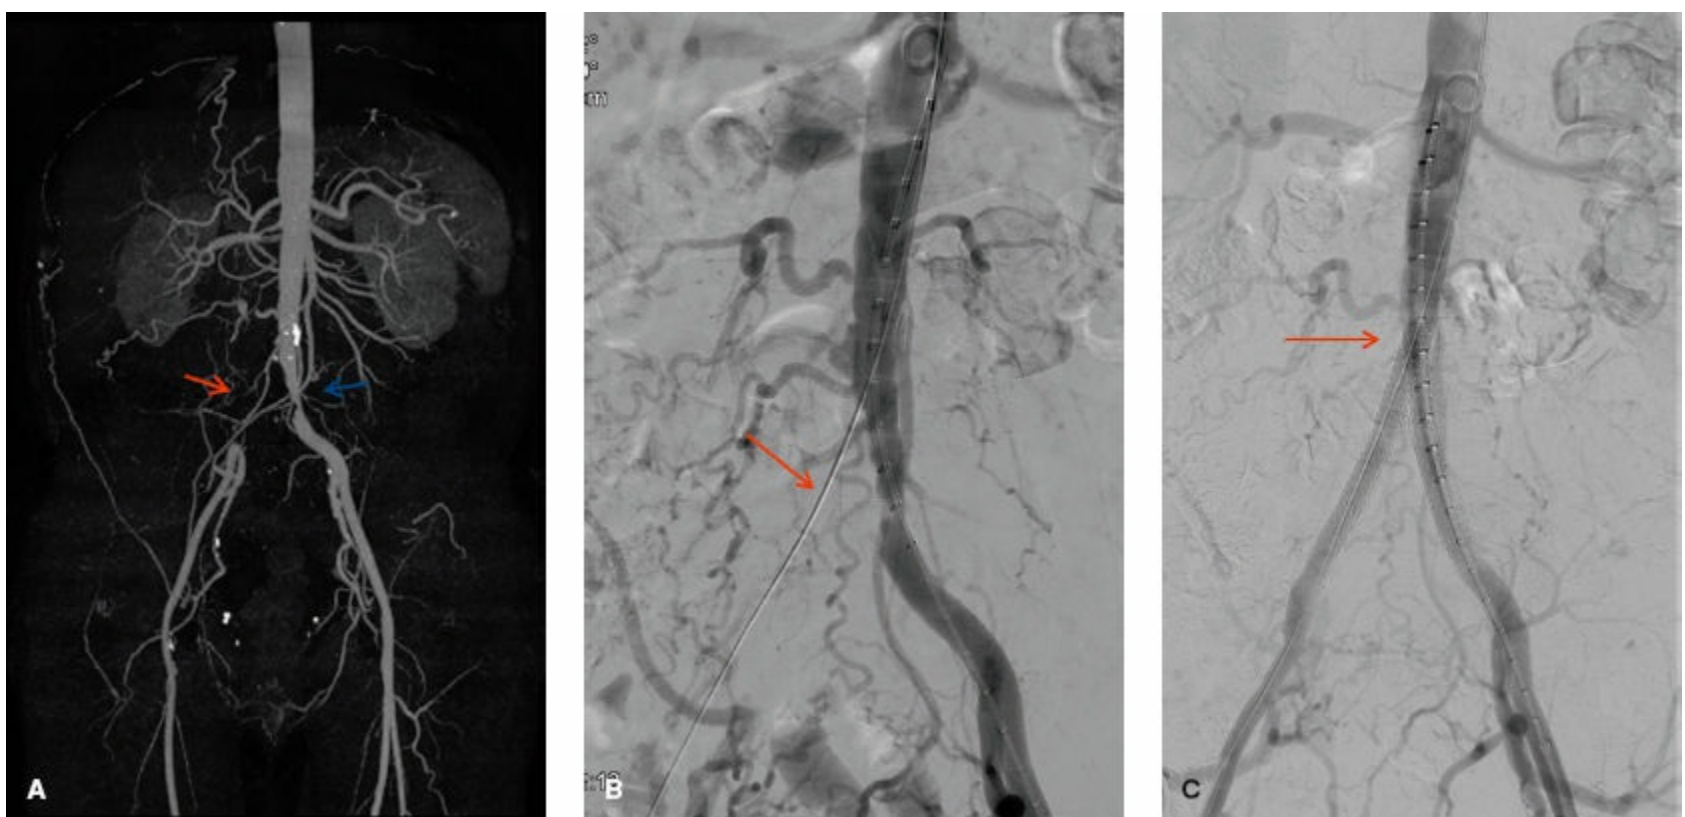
A: CTA 3D reconstruction demonstrating right common iliac artery chronic total occlusion (*red arrow*) and severe left common iliac artery stenosis (*blue arrow*). B: Abdominal aortogram redemonstrating right common iliac artery chronic total occlusion and left common iliac artery stenosis. Note successful wire traversal of the right common iliac artery occlusion (*red arrow*). C: Abdominal aortogram demonstrating successful endoluminal bilateral common iliac artery revascularization following percutaneous balloon angioplasty and stent placement. Note the “kissing” stents in the distal aorta (*red arrow*).
